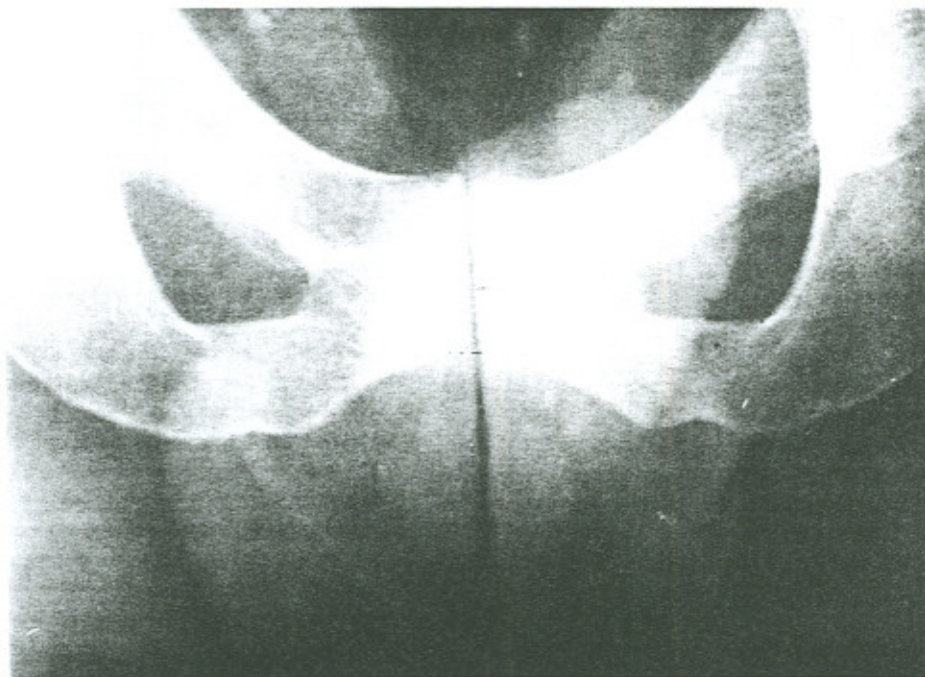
The typical radiographic features of osteitis pubis as noted in Table 1.
